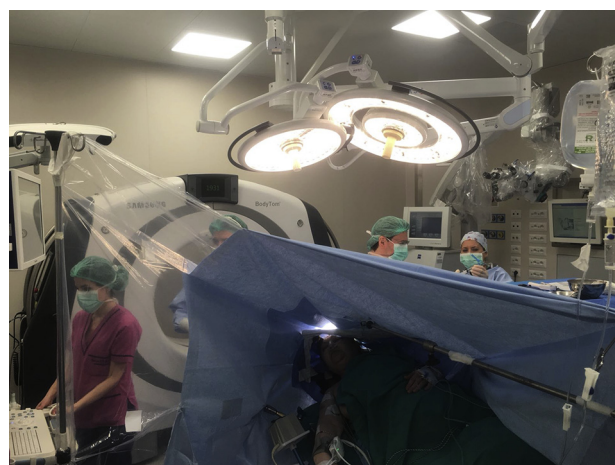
Case 4. Operating theatre during awake craniotomy aided by intraoperative computed tomography scan.
